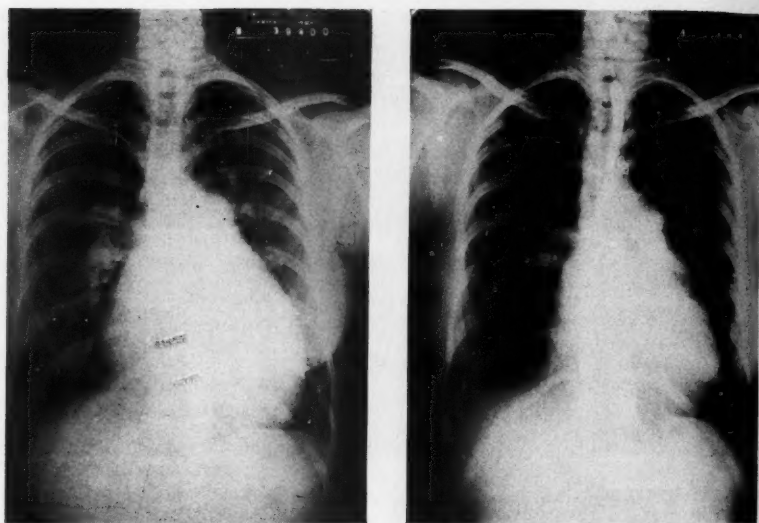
The preoperative chest roentgenogram is shown on the left and four months post-operative on the right. Decrease in heart size and decreased vascularity of the lung fields is apparent.
